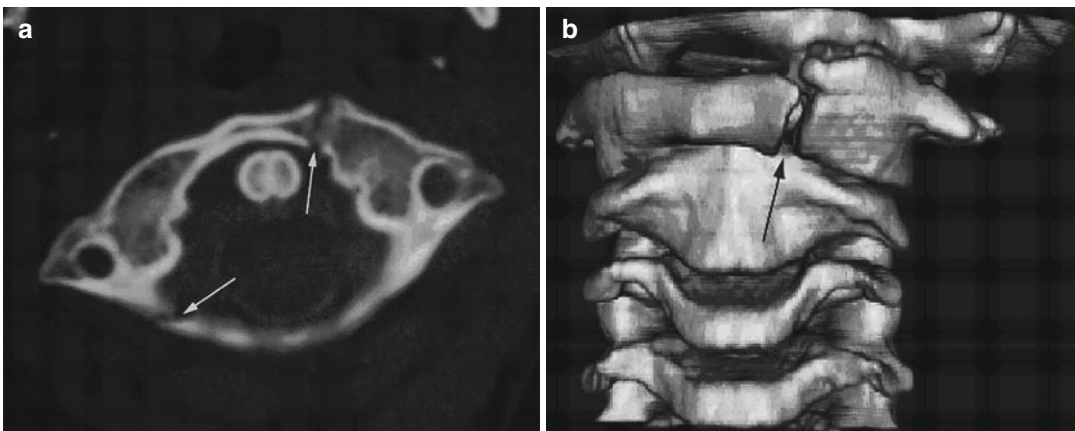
Axial CT scan through C1 (a) and three-dimensional reformatted CT scan of the upper cervical spine (b) obtained in a 6-year-old boy showing anterior
